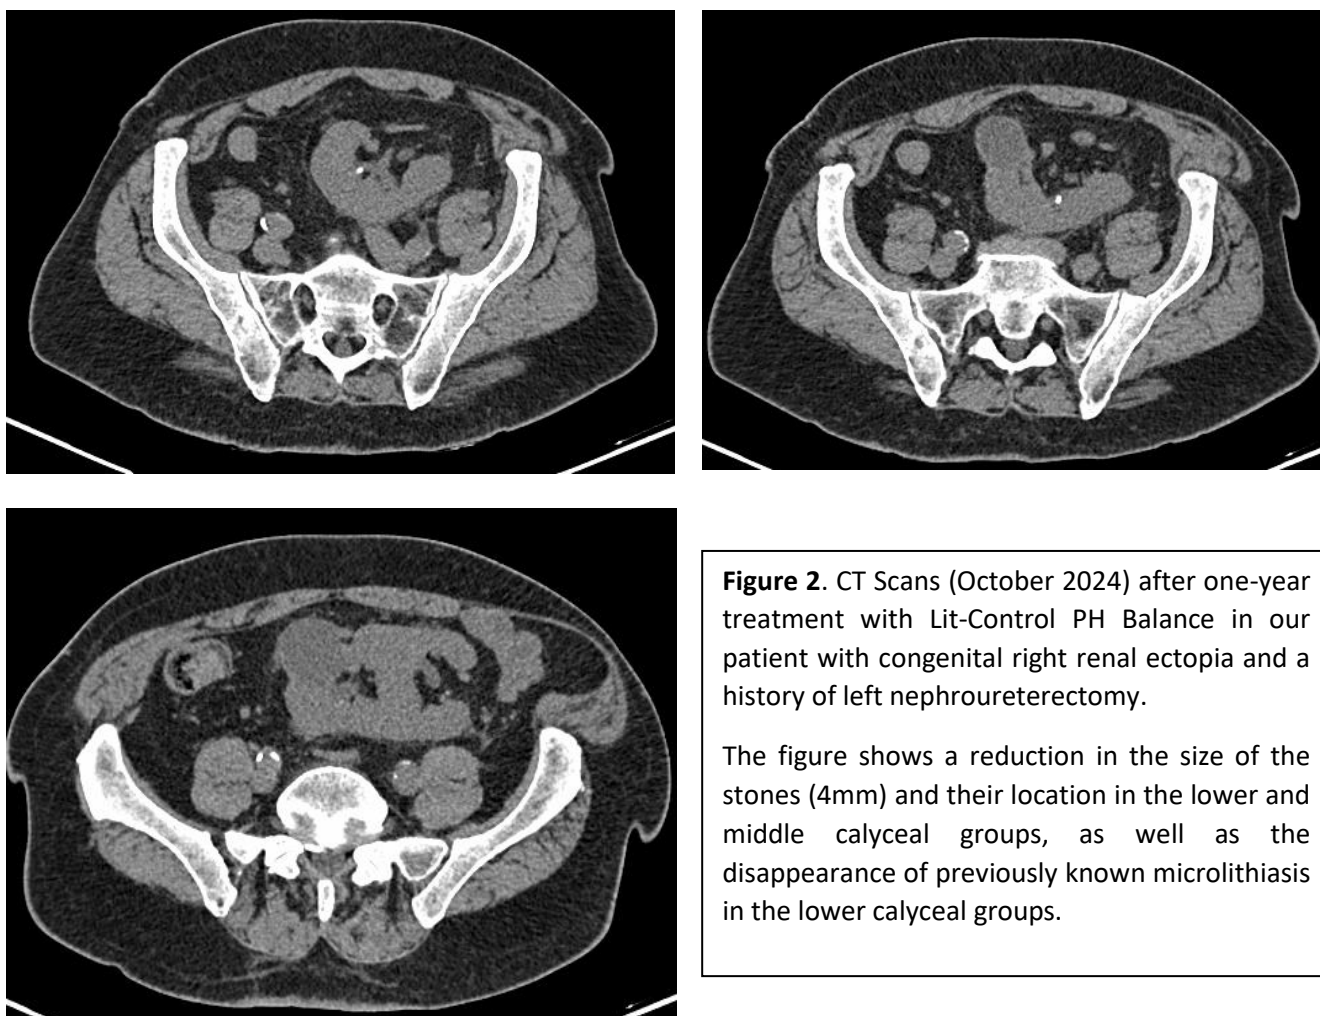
CT Scans (October 2024) after one-year treatment with Lit-Control PH Balance in our patient with congenital right renal ectopia and a history of left nephroureterectomy.
